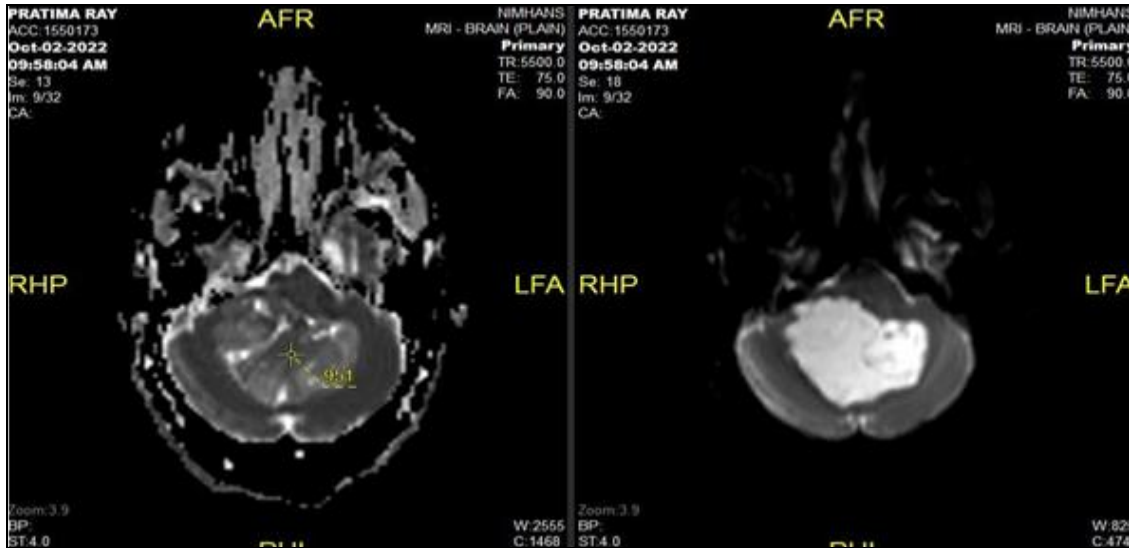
DWI AND ADC MR BRAIN IMAGES IN A CASE OF MEDULLOBLASTOMA SHOWING COMPLETE DIFFUSION RESTRICTION WITH SIGNIFICANTLY LOW ADC VALUES THUS DIFFERENTIATING IT FROM LOW GRADE EPENDYMOMA
